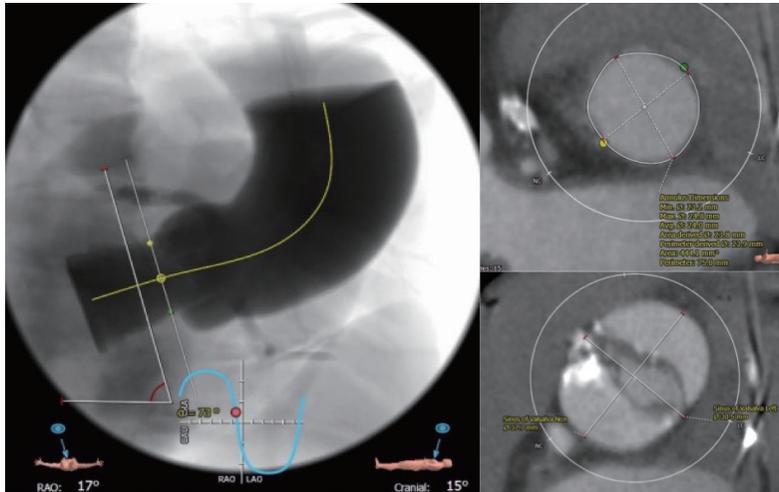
Contrast-enhanced CT showing analysis of the aortic valve.
